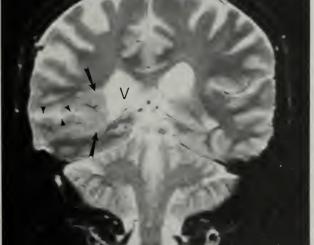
Coronal T2-weighted spin echo image demonstrates a horizontal CSF cleft (arrowheads) extending centrally from the cortex. A well-defined mass (arrows) at the medial cleft compresses the lateral wall of the right lateral ventricle (V).
